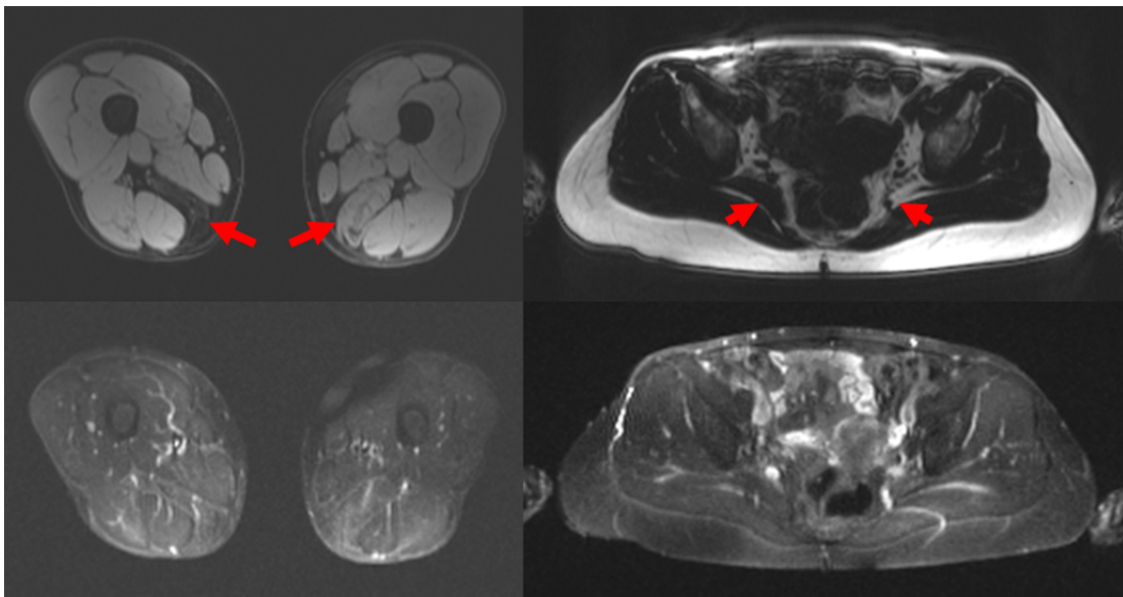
MRI of asymptomatic participants with FSHD confirmed by genetic testing. Left column: Fat-suppressed T1-weighted (above) and STIR (below) imaging of a 45-year-old male. Thigh imaging shows asymmetric fat infiltration (scored as 4 on the right, 2 on the left) of the semimembranosus muscles (arrows). There is a STIR hypointense area in the medial left thigh due to radiofrequency artifact from the MRI coil. Right column: Non-fat suppressed and STIR imaging of the pelvis of a 52-year-old female. The only abnormality seen on MRI was asymmetric absence of the left piriformis (arrows).
